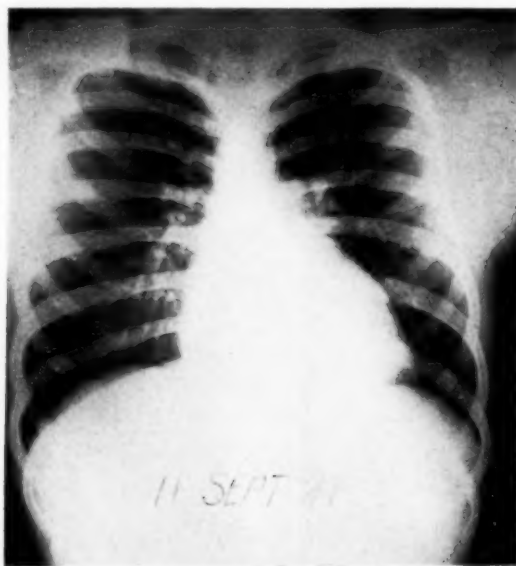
Roentgenogram of Case 3 showing enlargement of the heart, due primarily to left ventricular hypertrophy. The aortic knob is not visualized. (Courtesy of Letterman Army Hospital Photographic Laboratory. Neg. No. L-7129-1).
